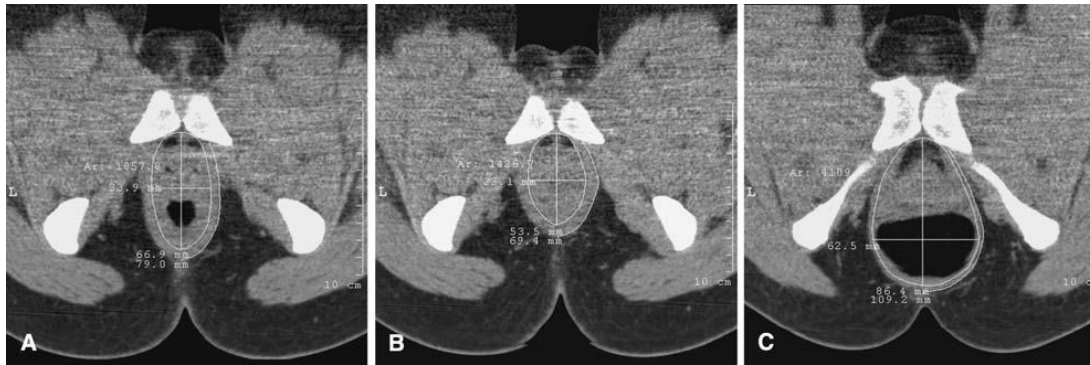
Seated CT defecography; images of puborectalis plane *A*) At rest, the puborectalis is lower case “u”-shaped *B*) During squeeze, the puborectalis shortens and becomes “v”-shaped; the centripetal force of the puborectalis shuts the genital hiatus and anus tightly *C*) During defecation, the puborectalis lengthens and becomes capital “U”-shaped; the centrifugal force of the levator ani opens the genital hiatus and anus.
